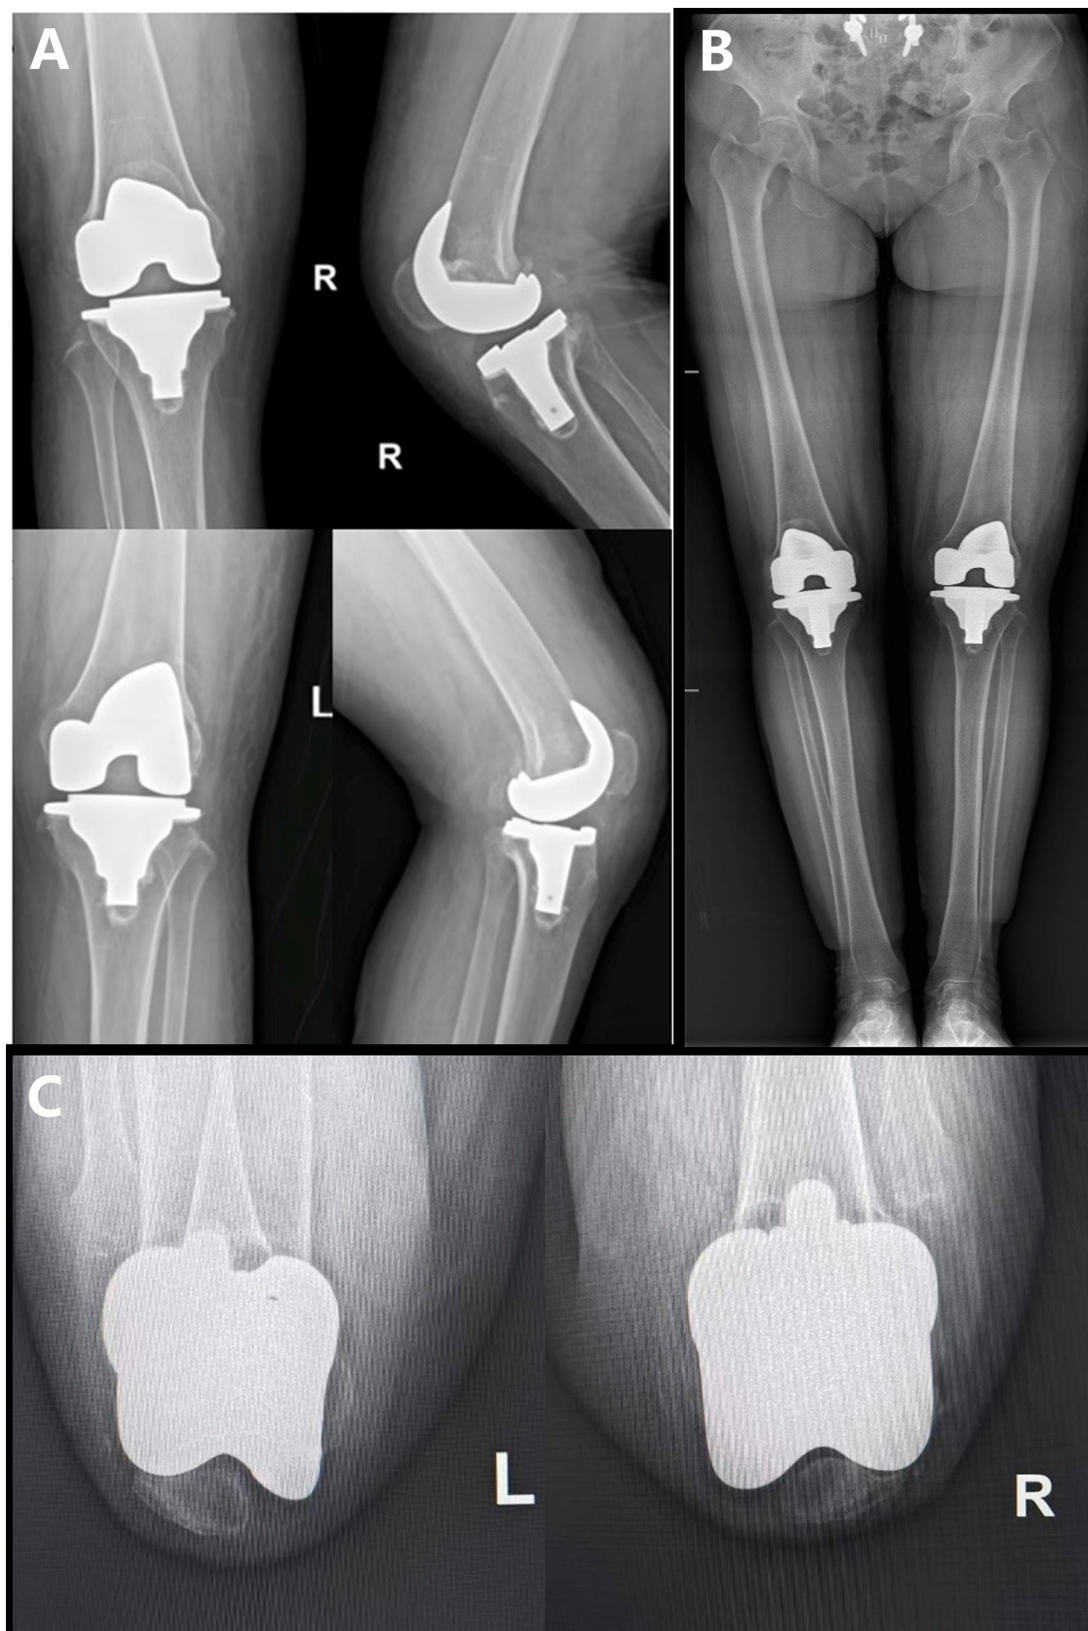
Postoperative X-ray following total knee arthroplasty. (A) Anteroposterior and lateral views of knees. (B) Full-length lower limb radiographs. (C) Patellar axial views.
